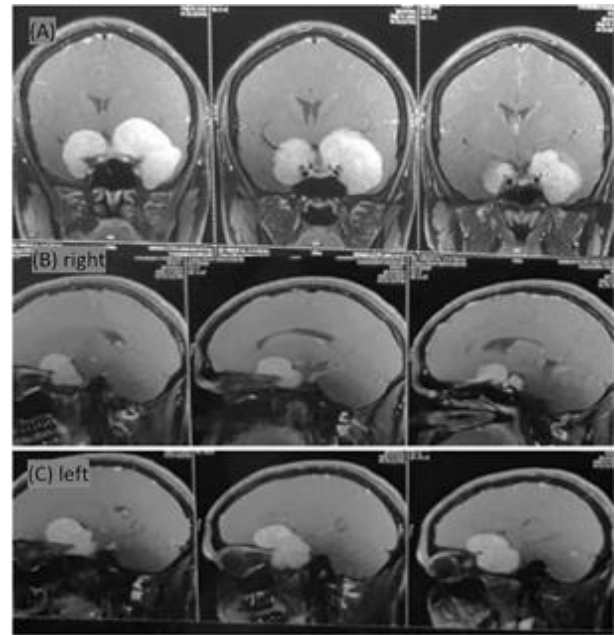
Preoperative MRI Brain with contrast showing bilateral clinoidal lesion (Saggital & Coronal images).
